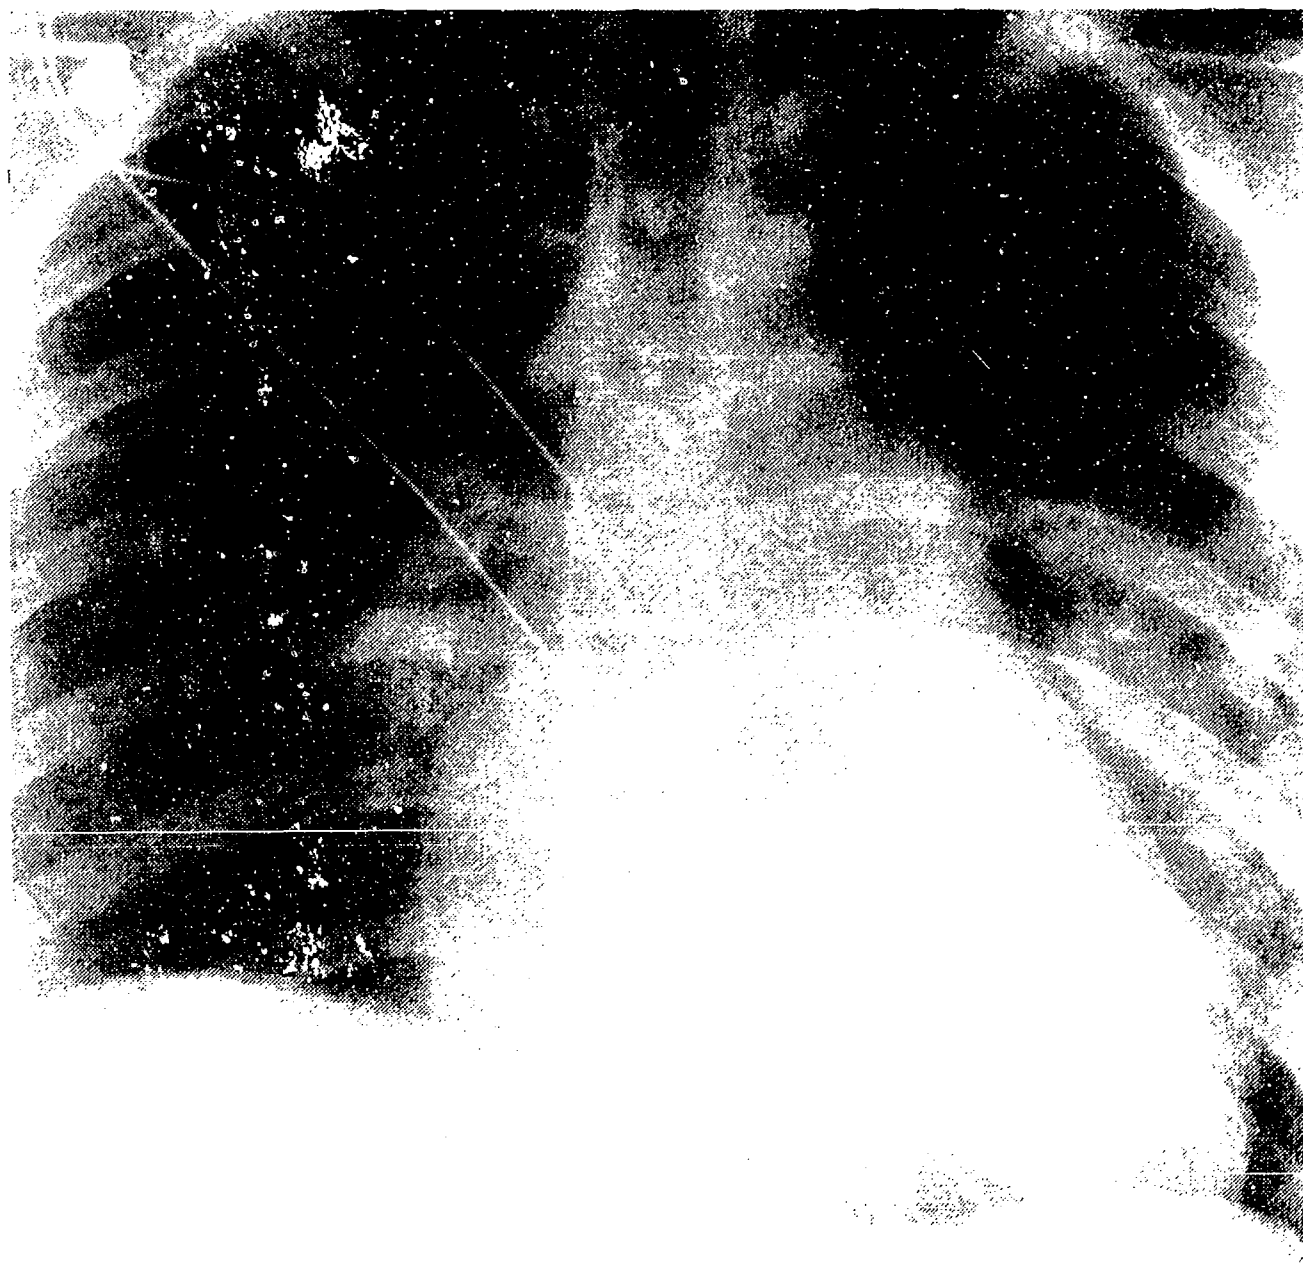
A chest roentgenogram of a patient in the supine position who had blunt thoracoabdominal trauma shows a patchy left midlung infiltrate consistent with pulmonary contusion but shows no evidence of barotrauma.
